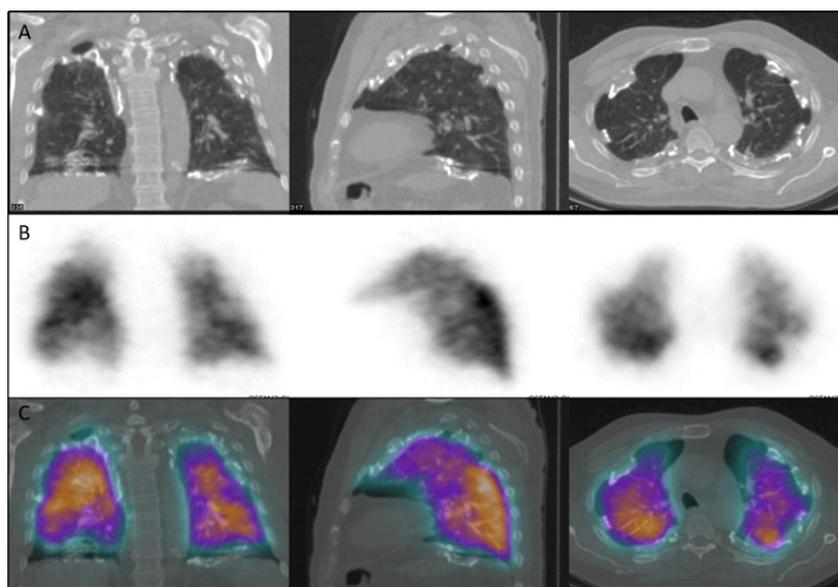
In a case with asbestosis, CT scan (line A- coronal, sagittal, and transaxial slice) helps identify calcified pleural plaques as the cause of perfusion defects on Q SPECT/CT imaging (line B). The fused SPECT/CT images (line C) show the perfusion defect corresponding to calcified pleural plaques, not parenchymal. Pulmonary thromboembolism was correctly excluded with Q SPECT/CT in this case, which is interpreted as non-diagnostic with Q SPECT.
